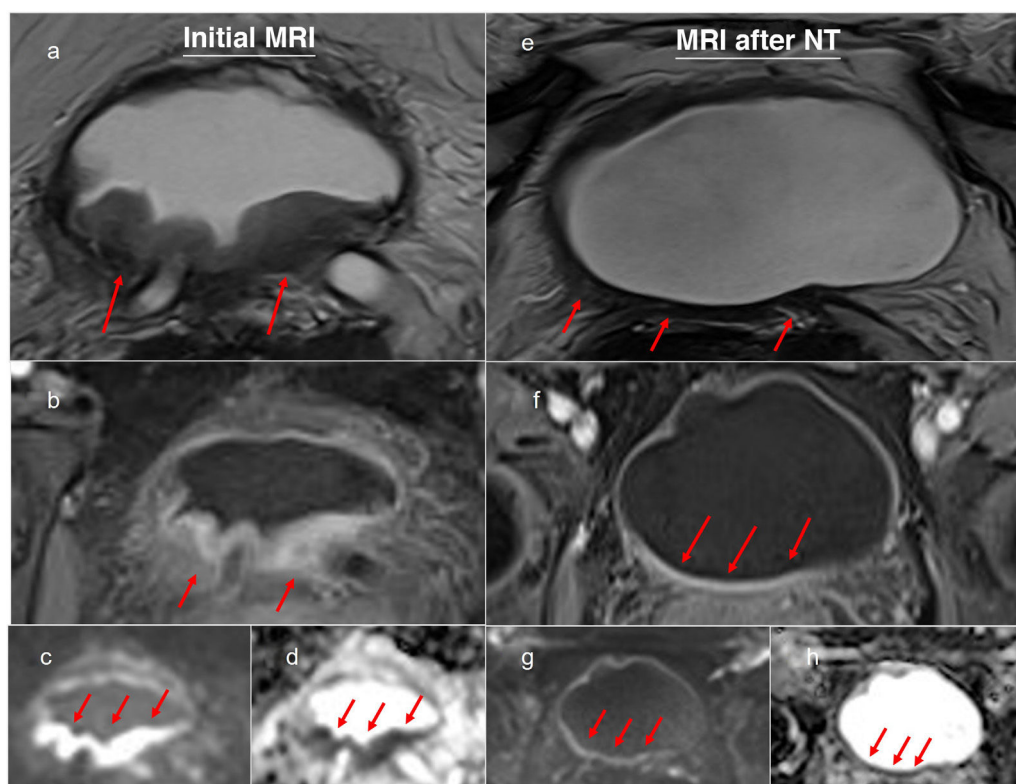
Patient with MIBT who is a candidate for neoadjuvant treatment. Initial pre-TUR MRI 9 (a-d). a) Axial T2. b) Dynamic contrast-enhanced (DCE) study. c) Diffusion (b1000). d) ADC. A sessile parietal thickening involving the posterior aspect, the bladder trigone and both ureters (segments 5, 1, 10, 11) is observed, which appears to replace and infiltrate the muscle wall with retrograde dilatation of both ureters (red arrows). The lesion was categorised as VIRADS® 4. TUR was performed with an anatomopathological outcome of T2. MRI performed after completion of neoadjuvant treatment (e-h). e) Axial T2. f) DCE. g) Diffusion (b1000). h) ADC. There is resolution of the trigonal parietal thickening with diffuse hypointensity of the muscle layer on T2, without diffusion restriction or early enhancement showing tumour remnants (red arrows). It was labelled as NAC-VIRADS® 1. Cystectomy was performed with an anatomopathological outcome of ypT0N0. (Images courtesy of Aránzazu Urresola. Hospital de Cruces, Barakaldo, Bizkaia.).
